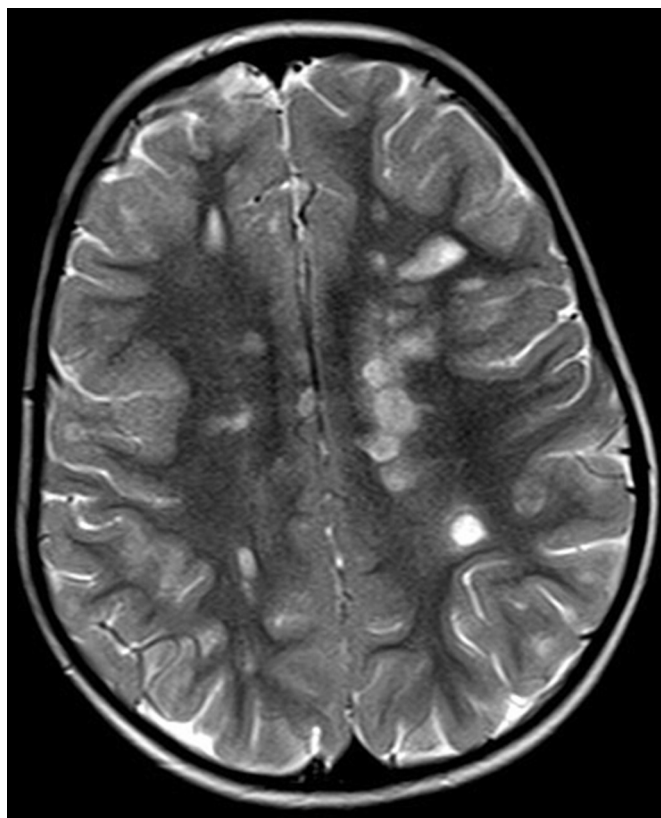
■ Acute disseminated encephalomyelitis. T2-weighted MRI showing multifocal areas of increased signal in the white matter. (From Wender M: Acute disseminated encephalomyelitis (ADEM). *J Neuroimmunol* 231:92, 2011, with permission from Elsevier.)
